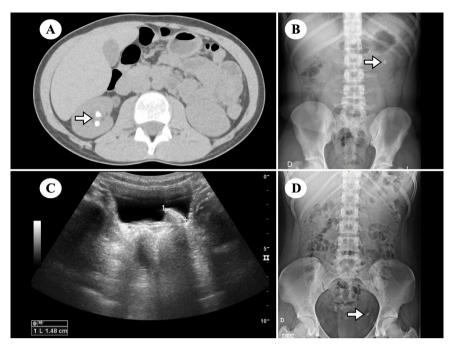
Different imaging modalities and calculi locations. Computed tomography scan showing 2 renal calculi (A, arrow), plain radiograph of the abdomen showing one calculus in the left kidney (B, arrow), ultrasound scan showing cystolithiasis (C) and a distal ureteral calculus (D, arrow).
